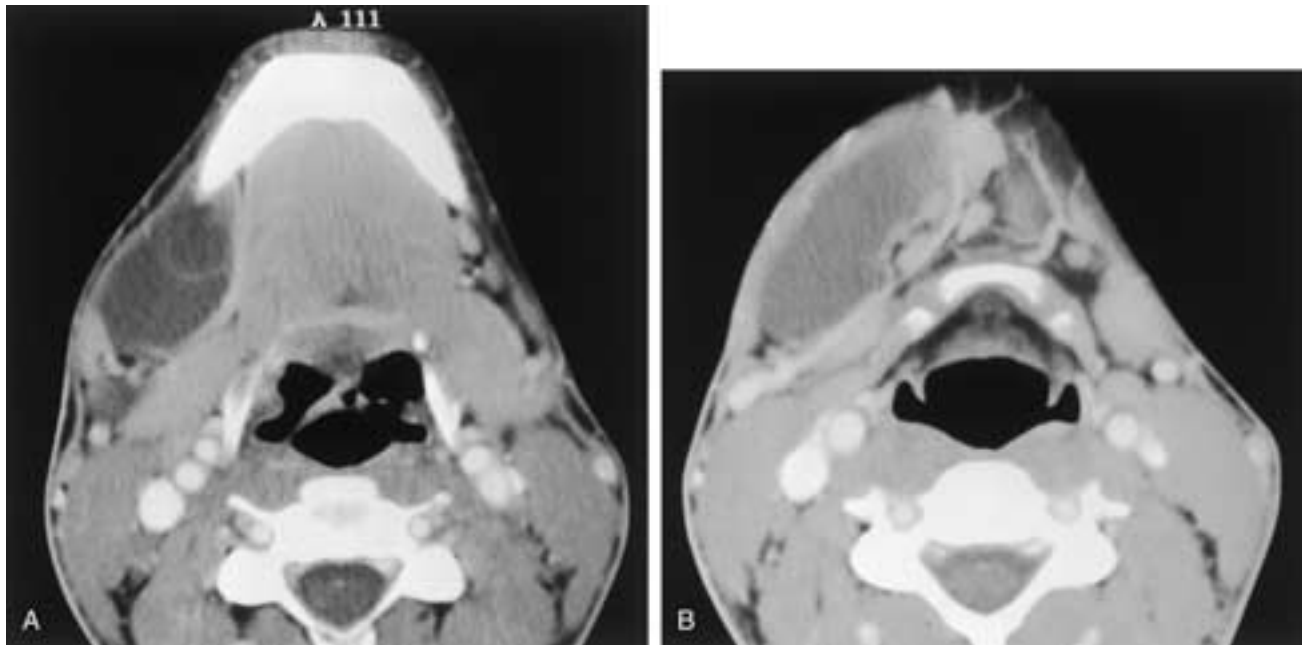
Extravasation mucocoele. Serial contrast-enhanced CT images (A and B) demonstrate a cystic lesion in the right submandibular space, clearly lateral and inferior to the mylohyoid muscle. The mucocoele wraps around the posterior margin of the mandible. The bulk of the mucocoele is at the level of the hyoid bone.
